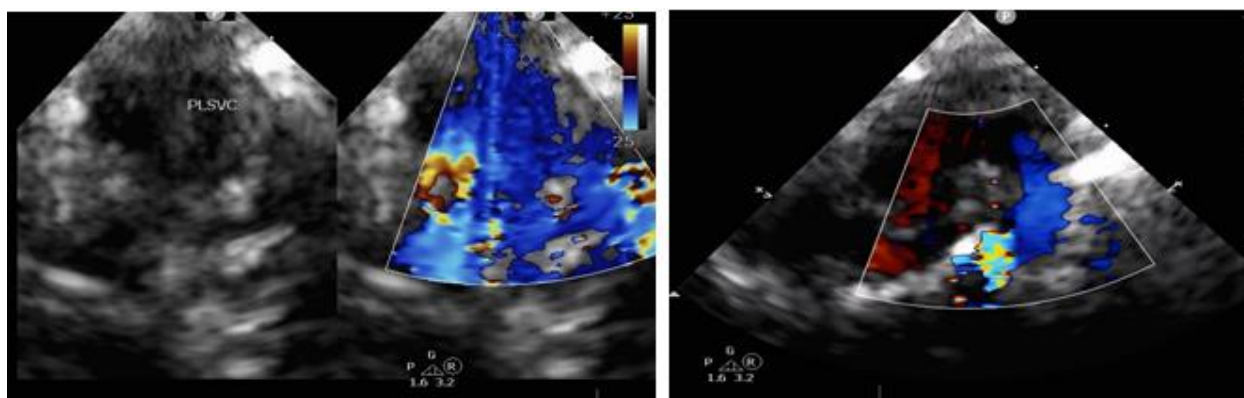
Echocardiograph:High parasternal (ductal) view showing lt superior vena cava (PLSVC).
